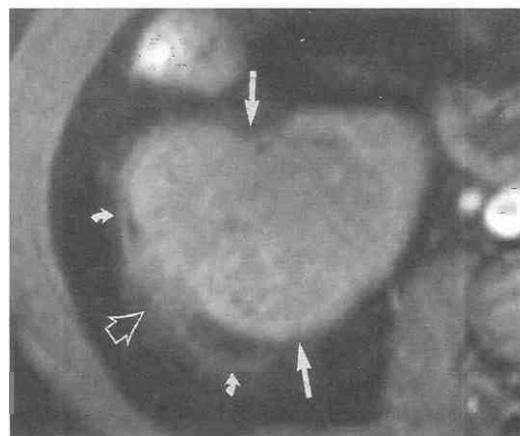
Renal cell carcinoma with early perinephric extension. Unenhanced fat-suppressed T1-weighted MR image (TR = 600 msec, TE = 15 msec) shows a large neoplasm (*straight arrows*) in the lower pole of the right kidney. There are early extension into the perinephric fat (*open arrow*) and associated renal fascial thickening (*curved arrows*).
